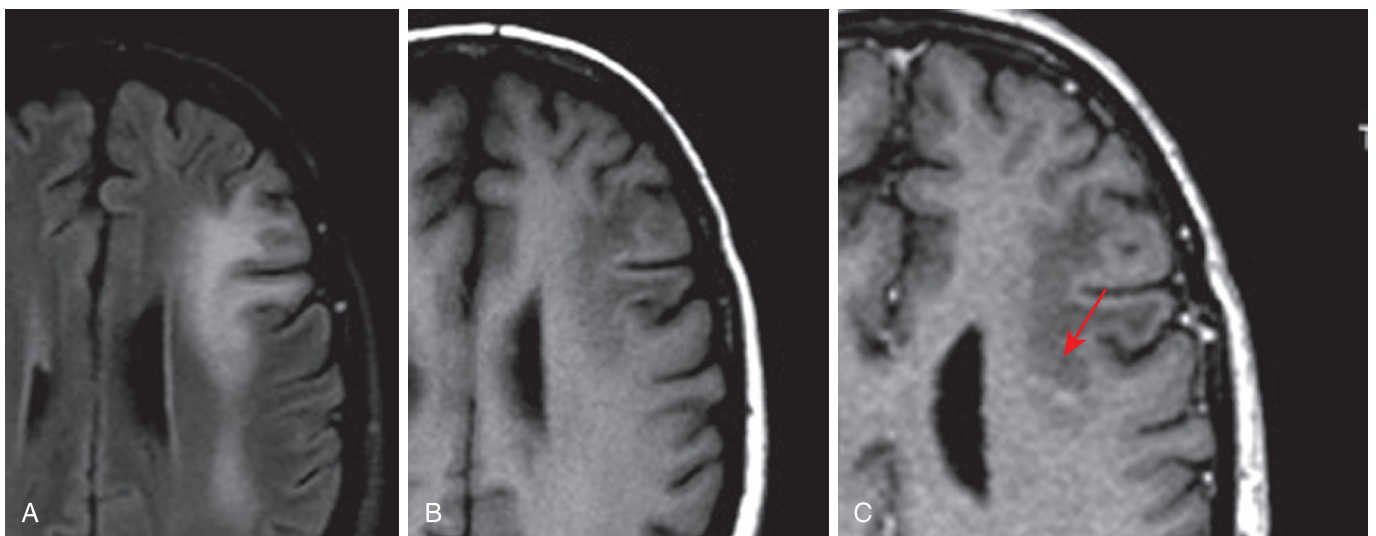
Inflammatory progressive multifocal leukoencephalopathy (PML) case example. A 48-year-old female, HIV positive, intermittently compliant with therapy. CD4: 137; cerebral spinal fluid: JC virus positive. Axial FLAIR (A), axial T1 precontrast (B), and axial T1 postcontrast (C) demonstrate a confluent white matter lesion with multifocal gadolinium enhancement (arrow).
